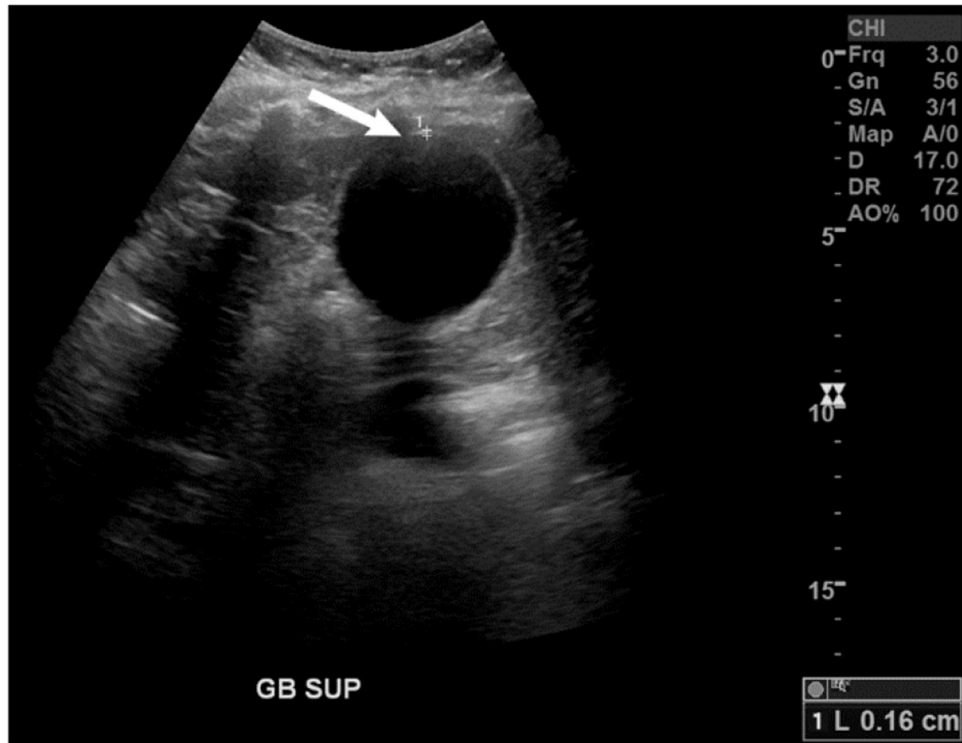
Transabdominal transverse ultrasound of the gallbladder shows a thin gallbladder wall (arrow), but with luminal distension to 5.1 cm measured on the short axis.
